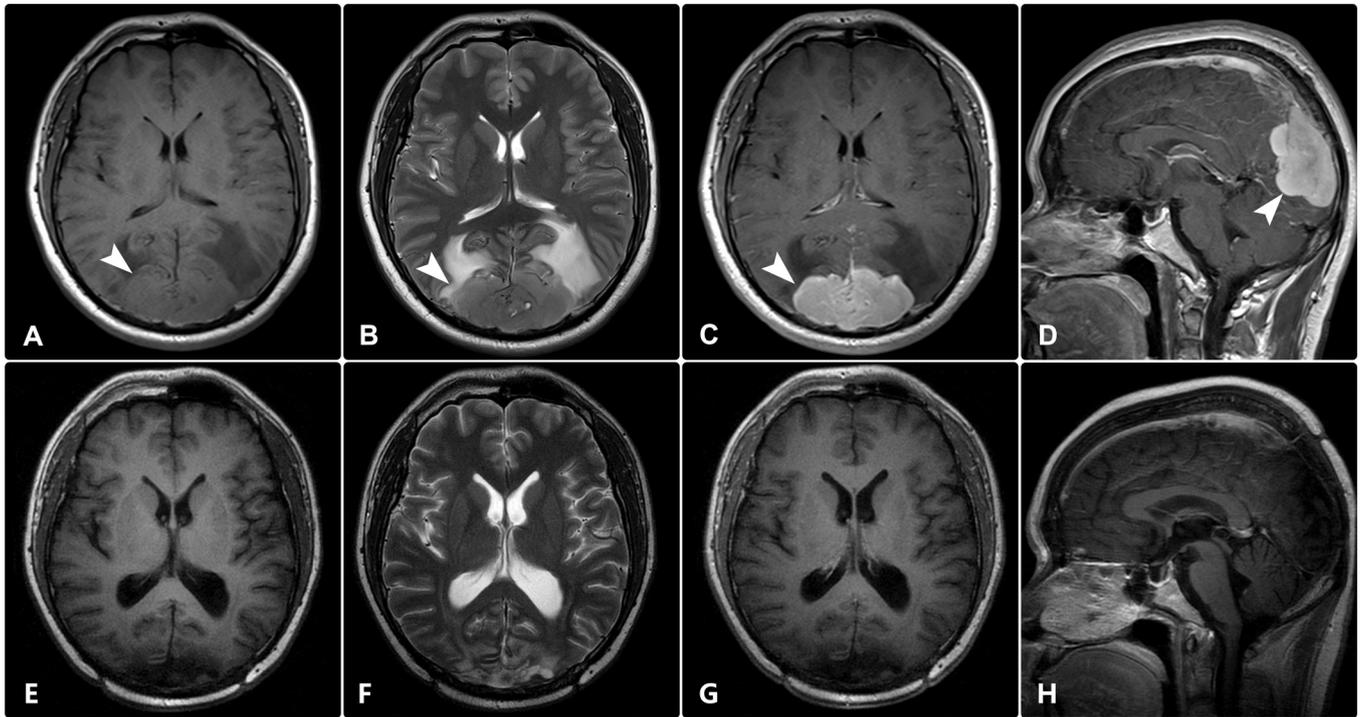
The cranial MR images show a parasagittal mass involving bilateral occipital lobes (arrowheads). The lesion is isointense on axial T1-weighted images (A), and mildly hyperintense on axial T2-weighted images (B). After Gd-DTPA administration, the axial (C) and sagittal (D) images show homogeneous contrast enhancement. The corresponding MR images in the last follow-up (E–H) show tumor-free patterns.
